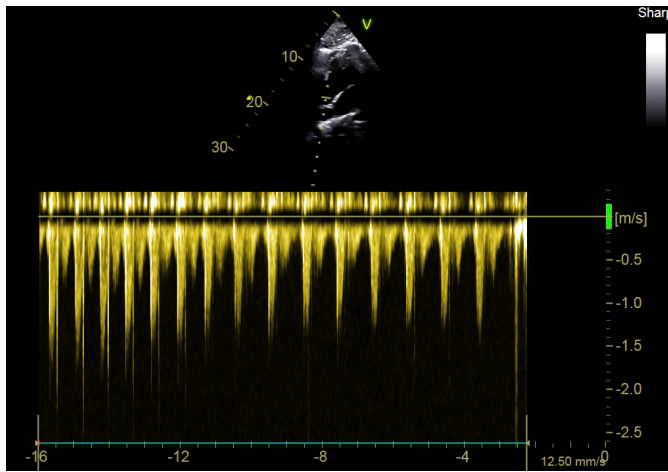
Transthoracic echocardiography immediately following a breath in a bottlenose dolphin. The image shows the Doppler flow profile at the left ventricular outflow tract using continuous flow Doppler. The flow begins as the aortic valve opens, which increases the flow velocity up to its maximum peak velocity, followed by a continuous decrease until aortic valve closure. The figure shows how heart rate (f_H ; duration between peaks) and stroke volume (SV; area under each curve) changes throughout the interbreath interval.
